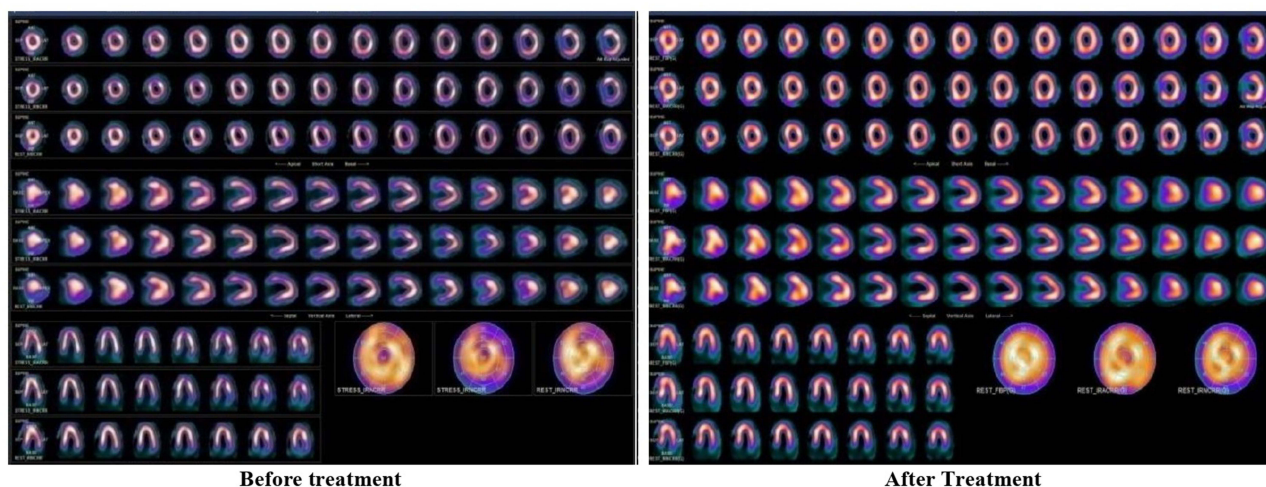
SPECT image before and after treatment.
